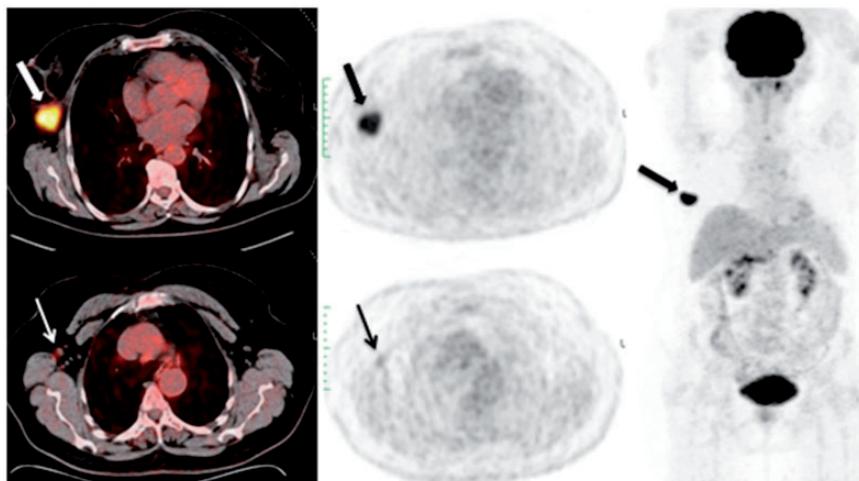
False positive of PET/CT. The primary lesion was detected on the outer part of right breast (upper row axial fused and PET images and on the right side MIP-image, thick arrows). A lymph node with mild FDG uptake about 1 cm in diameter was reported as metastatic (bottom row axial fused and PET images, thin arrows), however there was no evidence of metastasis to the axillary lymph nodes in pathology.
